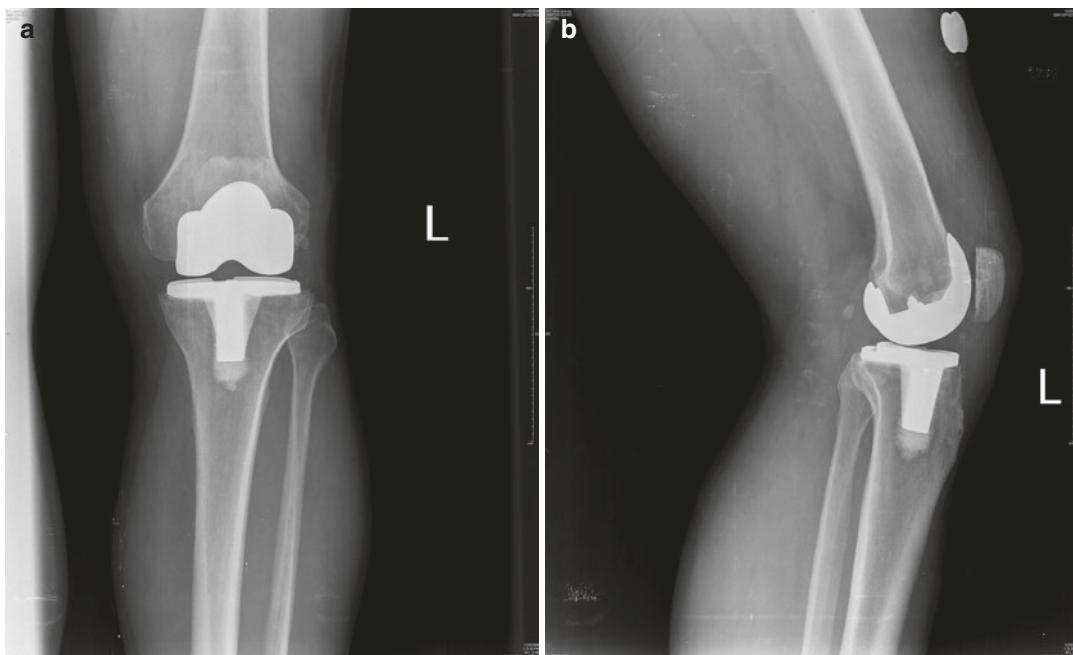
Anteroposterior (AP) (a) and lateral (b) radiographs of the left knee showing a cemented posterior stabilized arthroplasty. Note the small femoral component and decreased posterior femoral offset
